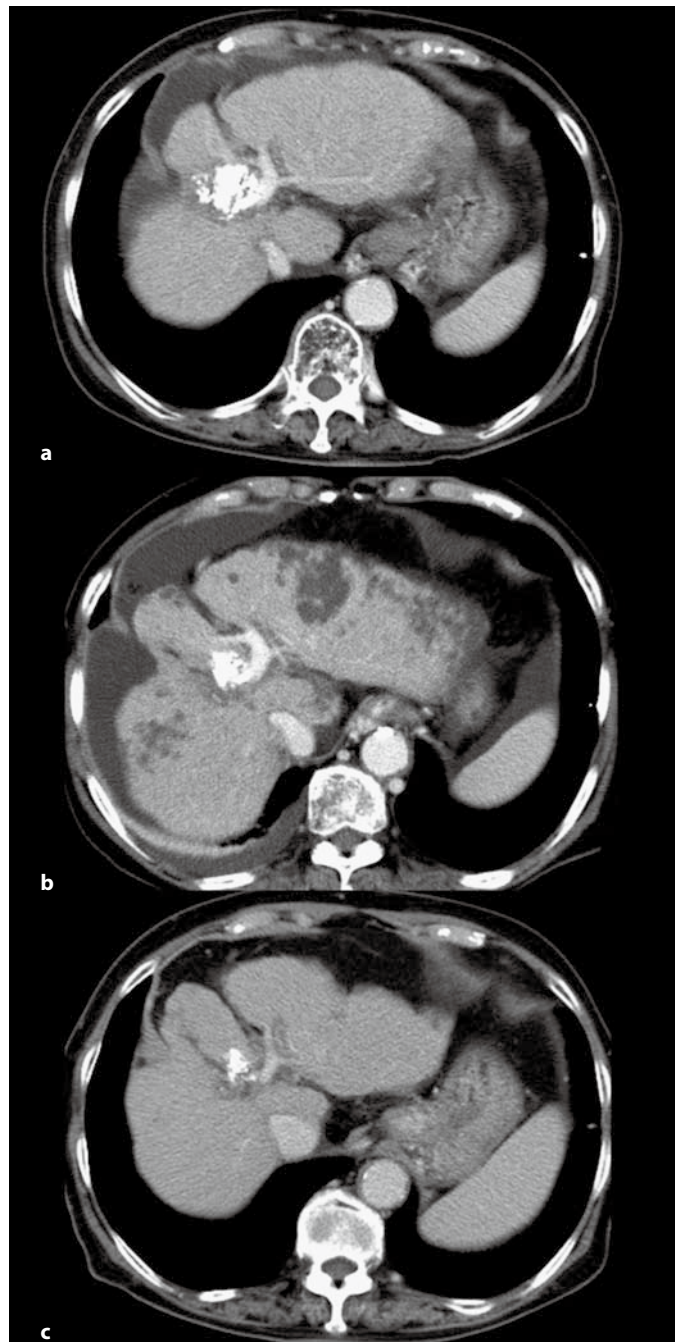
Changes in abdominal CT scans after cessation of sorafenib therapy. a CT taken when sorafenib therapy was suspended because of hepatic encephalopathy and deterioration of liver function. b Four days after a, ALT and AST levels rose dramatically to 1,454 and 1,653 IU/l, and CT scan revealed the presence of multicentric hepatic necroses in the right and left lobes of the liver. c CT at the most recent follow-up revealed slight atrophy of the left lobe of the liver but no recurrence of HCC.
